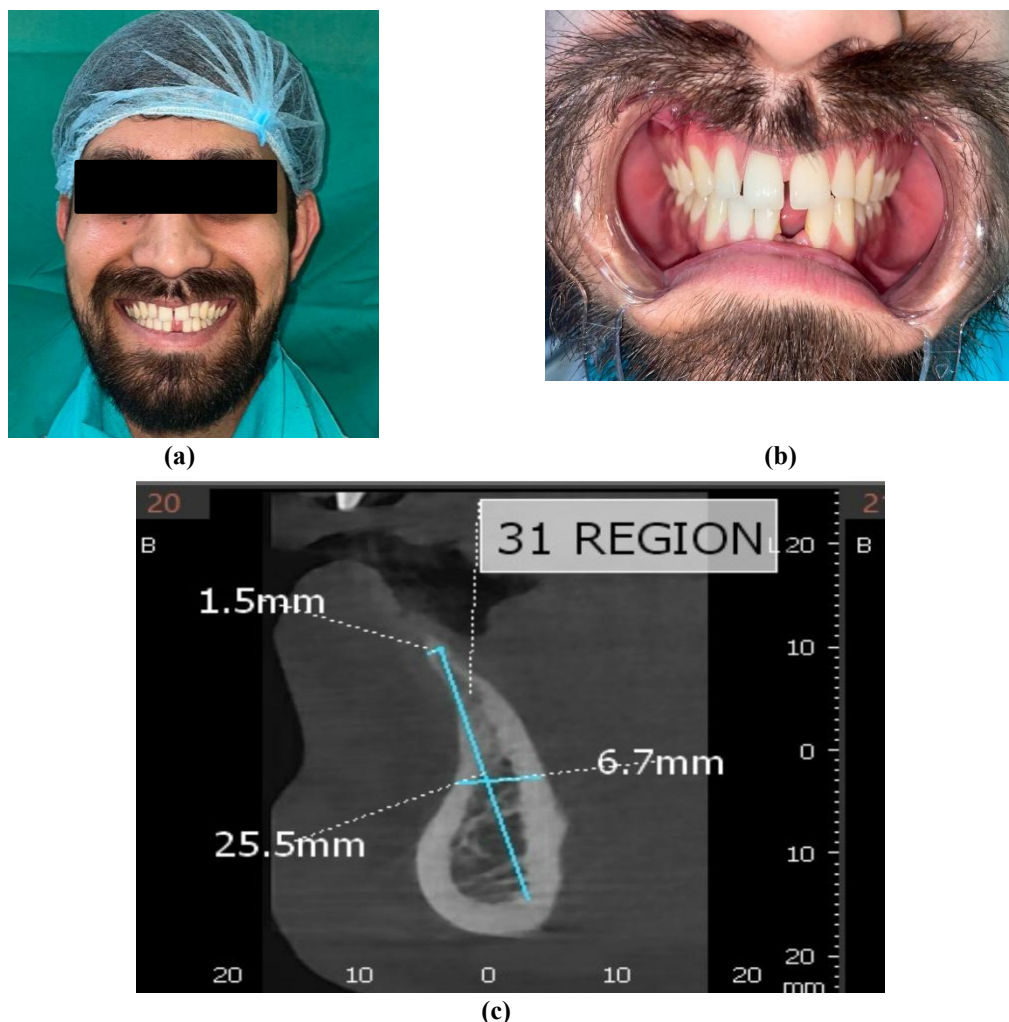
(a) Pre-op Front Profile (b) Intraoral Photograph (c) Saggital section of CBCT depicting measurements.
